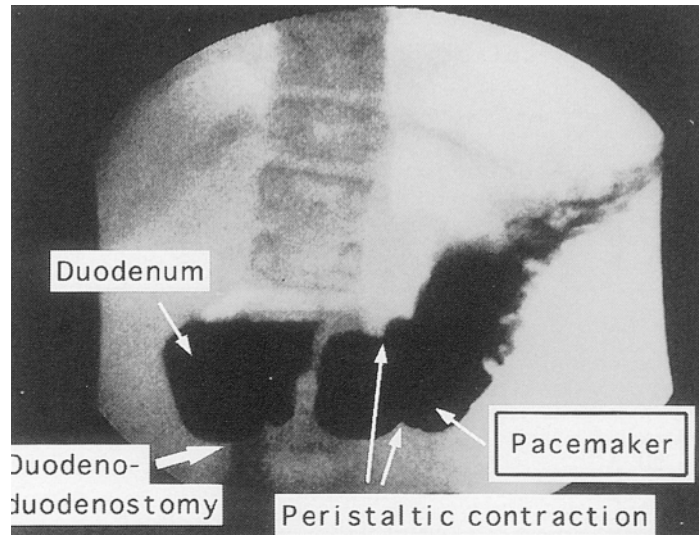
Site of a possible electrical pacemaker. Radiograph (upright AP view) obtained by fluoroscopic barium swallow study in case 3 (Table 1). Peristaltic contraction is well visualized, and the location of potential pacemaker site can be identified ectopically far distal along the greater curve.
